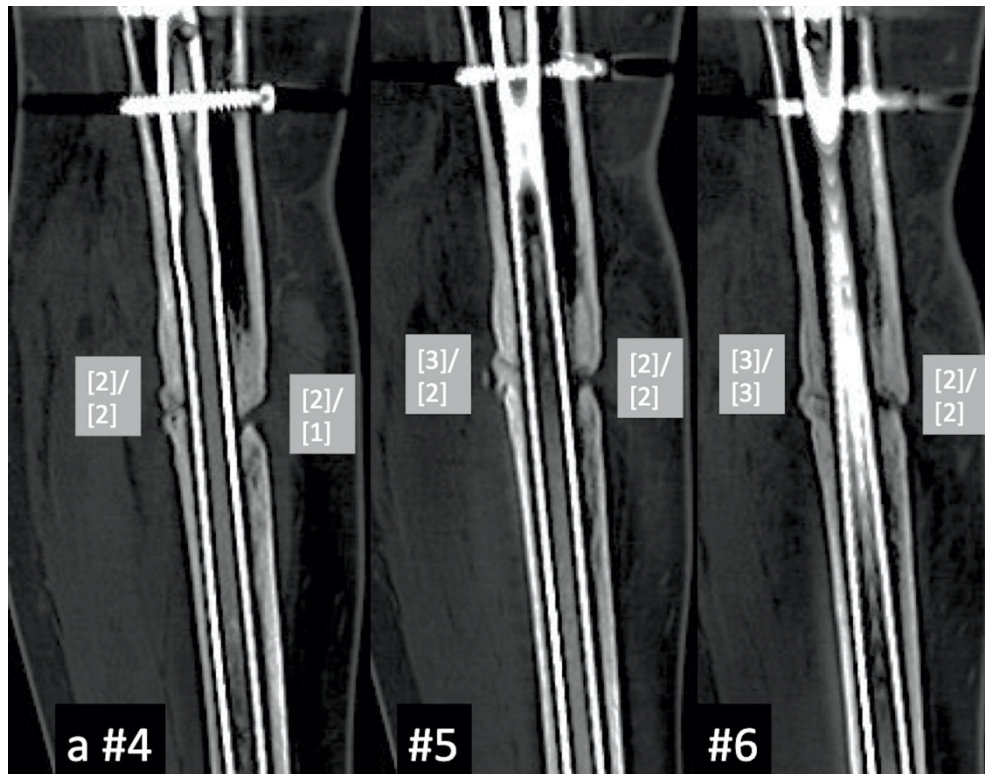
(a) Median (#5) and paramedian (#4 and #6) coronal, (b) sagittal and (c) transverse CT reformats of a nailed non-united tibial fracture. Numbers in brackets indicate scores given by reader 1 / reader 2, respectively. The ratio between the sum of the scores and the maximum score obtained on the three median reformats (9/16 for reader 1 and 8/16 for reader 2) is very close to that obtained on the two paramedian reformats (22/48 for reader 1 and 20/48 for reader 2). Non feasible (NF) scores are noted on transverse reformats because of metal artifacts.
